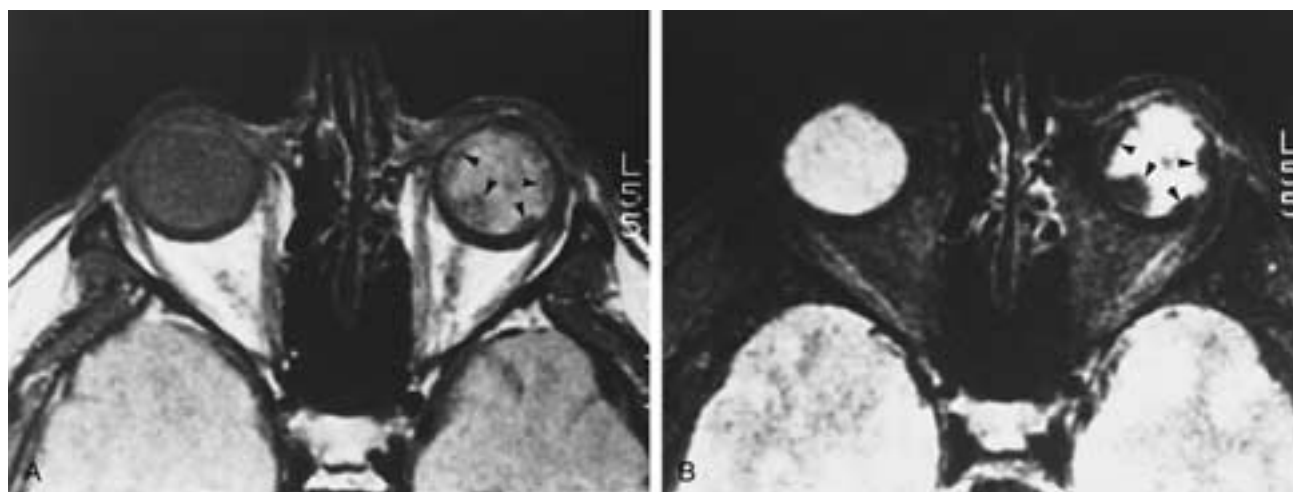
Acute choroidal hemorrhage (detachment). A, Axial PW and B, T2-weighted MR images. Scans show choroidal hematomas (*arrowheads*). The increased intensity of the left globe is probably caused by protein leaking into the vitreous as a result of an impaired retinal-blood barrier. (From Mafee MF et al. Retinal and choroidal detachments: role of MRI and CT. *Radiol Clin North Am* 1977;25:487-507.)
